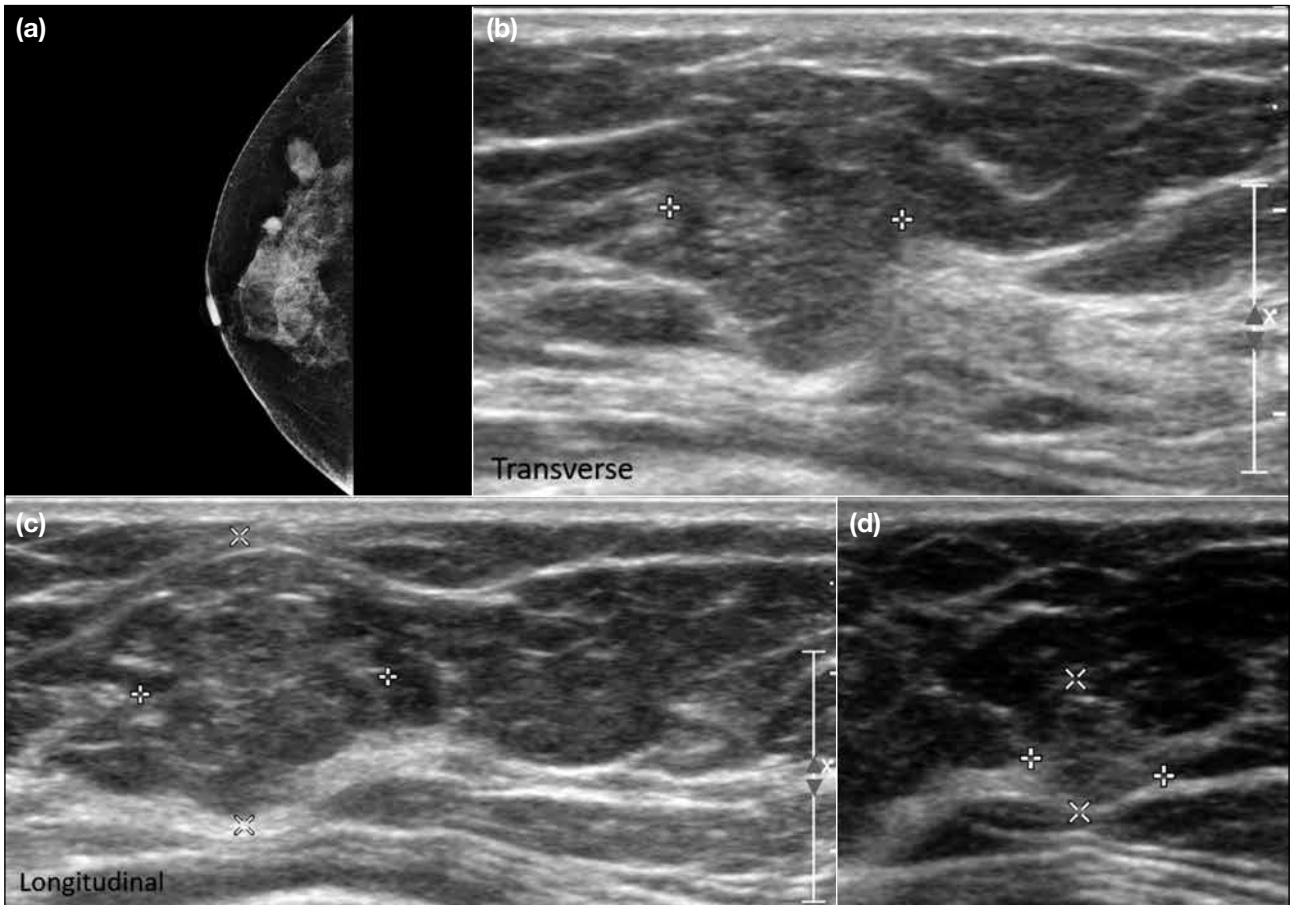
(a) Right craniocaudal mammogram of a 71-year-old woman showing two irregular high-density lesions at the outer part of the right breast, the more lateral one with indistinct margin, and the more medial one with spiculated margin. (b-d) Ultrasonograms showing a hyperechoic non-parallel lesion with indistinct margin corresponding to the more lateral lesion. A smaller hyperechoic non-parallel lesion with indistinct and slightly angulated margin is noted corresponding to the more medial lesion. Biopsy of the two lesions confirmed multifocal invasive ductal carcinoma at the upper outer quadrant of right breast.
